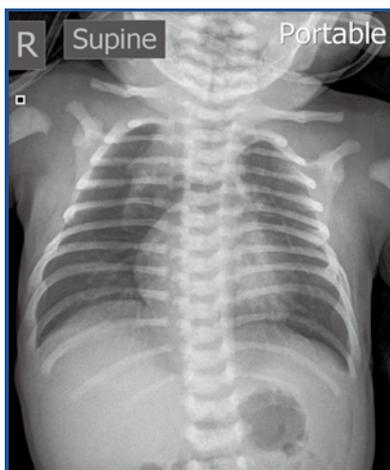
Frontal chest radiograph of neonate (A).
